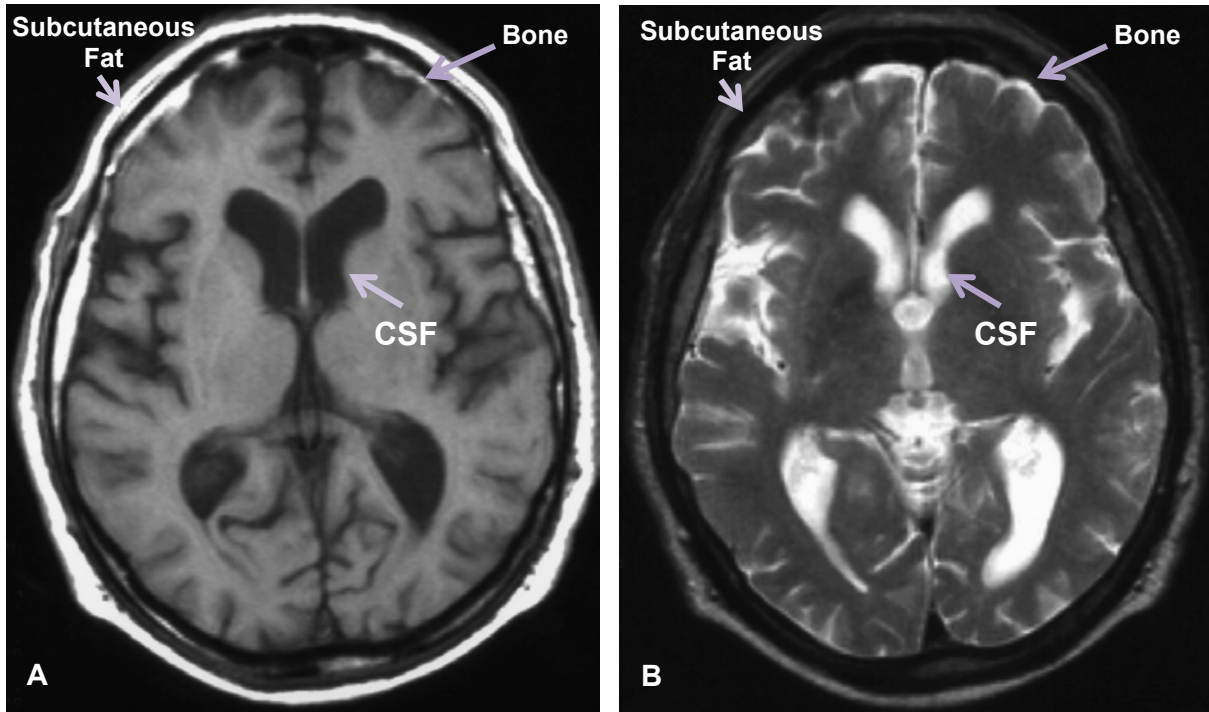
MRI of the brain. (A) T1-weighted axial image. (B) T2-weighted axial image.
